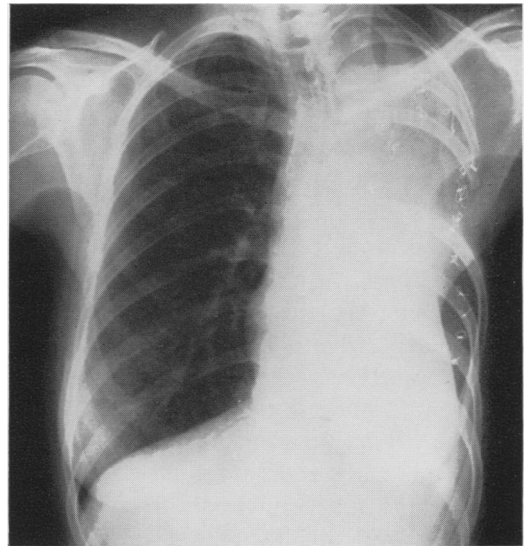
Case 6. A.P. chest x-ray film demonstrating metal sutures outlining the prosthesis.
